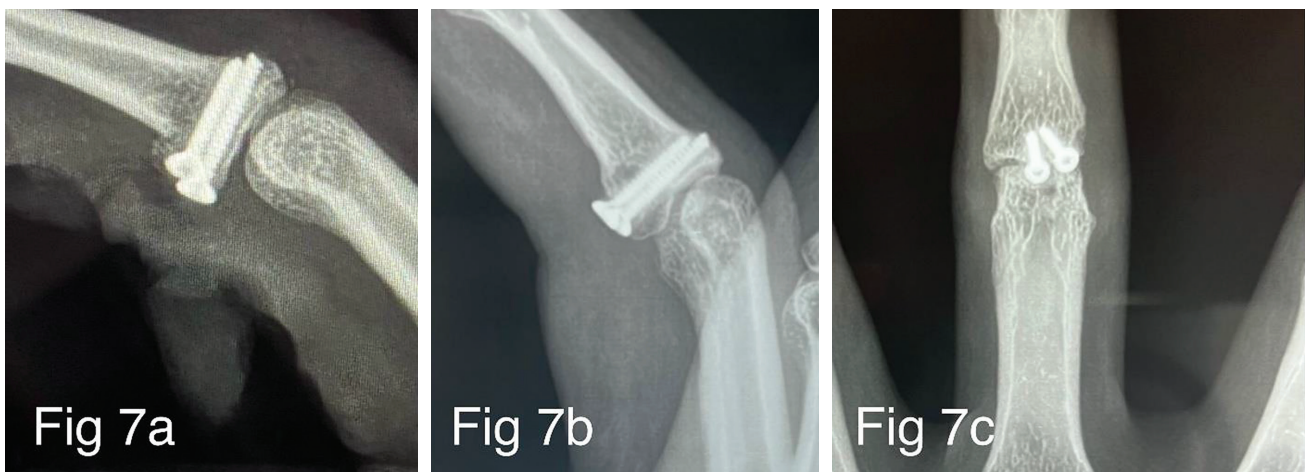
Radiograph immediately post-op (A) showed stable reduction. Concavity was a little flat. Radiographs at 36 months follow-up: Lateral and AP views showed signs of remodeling with improvement in the concavity of the graft, which appeared more “flushed” (B and C).
